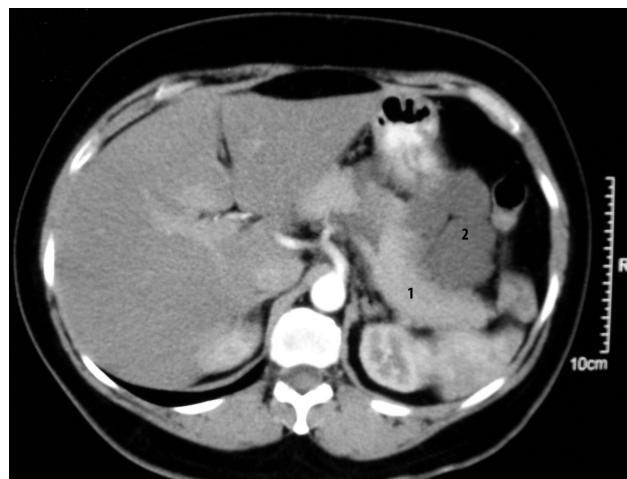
Abdominal CT scan revealed a lobulated hypodense cystic mass 9x12 cm in diameter originating from the tail of the pancreas. Pancreas (1) and cystic mass (2).
